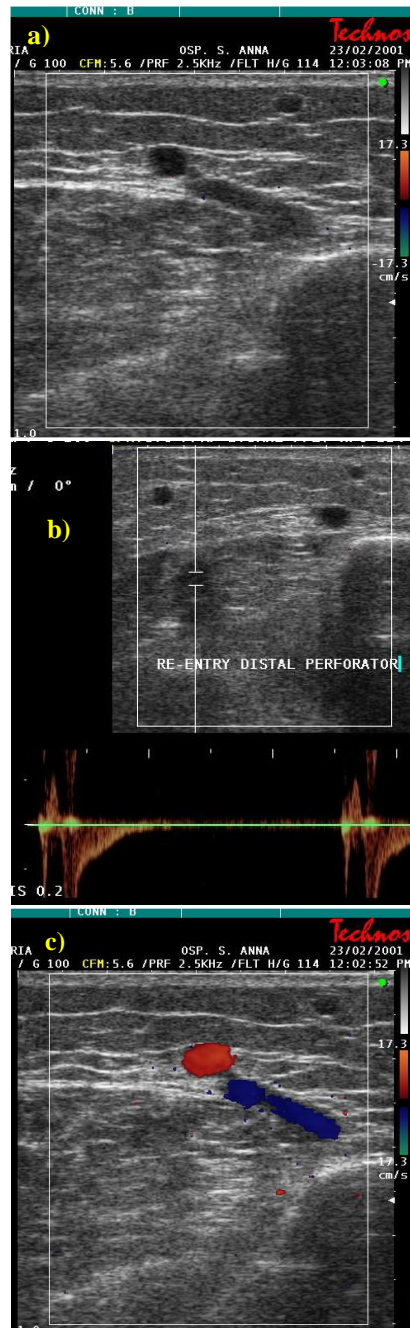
a) B mode image providing morphological information of saphenous vein connected with a perforating vein. b) The velocity-meter and flow direction Doppler information thanks to the Doppler sample of a duplex system placed into the perforating vein. c) The coloured-Doppler integrated information shows flow direction in both saphenous and perforating vein.
